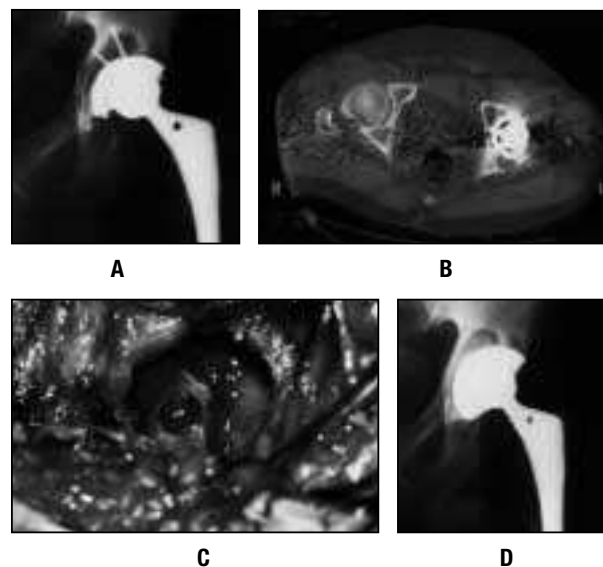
Case report of a 46-year-old man with a loosened acetabular component and pelvic osteolysis. A, Preoperative radiograph. B, CT scan of the loosened component that had collapsed into an osteolytic defect. C, Defect seen intraoperatively. D, Six-month follow-up radiographs showing a stable component and allograft incorporation.
